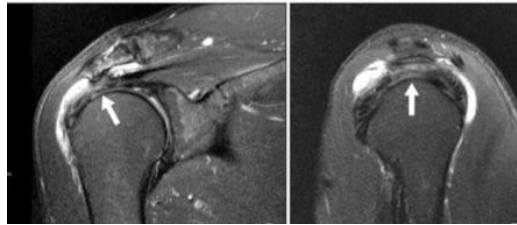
shows high-grade partial-thickness tear of right supraspinatus tendon tears (arrow) in coronal and sagittal planes of fat saturated T2-weighted MR images in Normotensive patient
